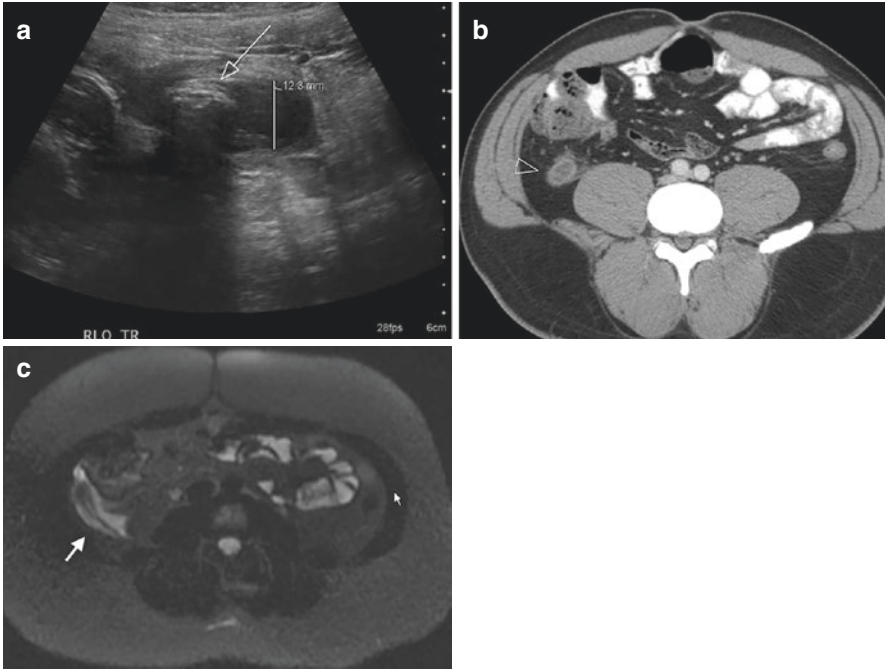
(a) Ultrasound of the right lower quadrant demonstrating a dilated appendix (12.3 mm) with an appendicolith in the lumen (arrow). (b) CT scan of the abdomen and pelvis at the level of the iliac crests demonstrating a dilated appendix (arrowhead) with surrounding inflammatory change. (c) MRI of the pelvis, using T2* weighted fat suppression technique demonstrating a mildly dilated appendix with surrounding edema. (Source: Authors from first edition)
